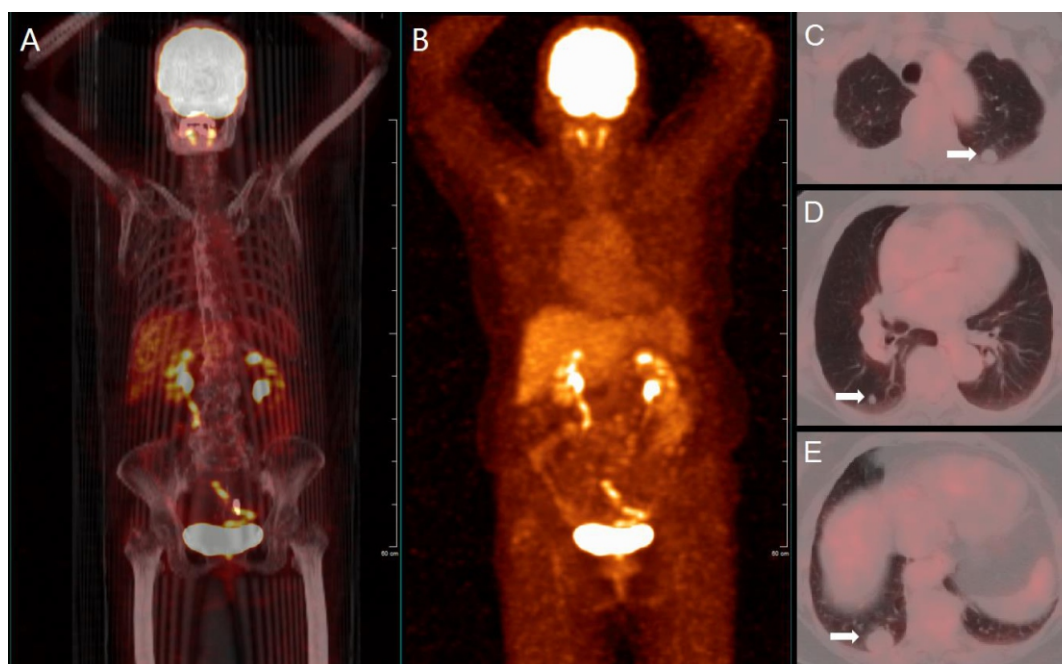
A 74 years old female had multiple pulmonary nodules on the computed tomography (CT) scan on a routine medical examination. Fluorine-18 fluorodeoxyglucose (^{18}F -FDG) positron emission tomography/CT scan followed. Maximum intensity projection image demonstrated a whole body normal uptake (early and late anterior views) (A-B). Multiple pulmonary nodules with no ^{18}F -FDG uptake were found on the fusion transaxial images (C-E, arrows).
